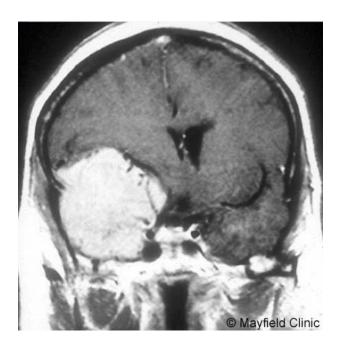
MRI of a sphenoid wing meningioma. The tumor has filled the area where the temporal lobe normally lies and has compressed the arteries and nerves causing vision problems.
